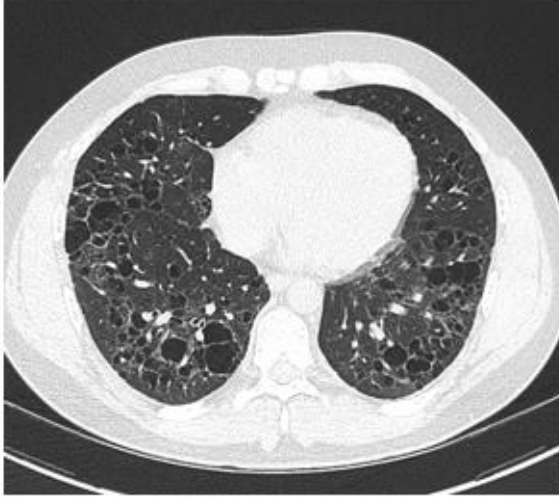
CT imaging 9 months post autologous stem cell transplant revealing no new cysts nor nodules. Compared to CT imaging 5 months pre-transplant, a pulmonary nodule in the right apex had decreased from 7mm to 5mm and a 9mm nodule in the right minor fissure had shrunk from 12mm.
